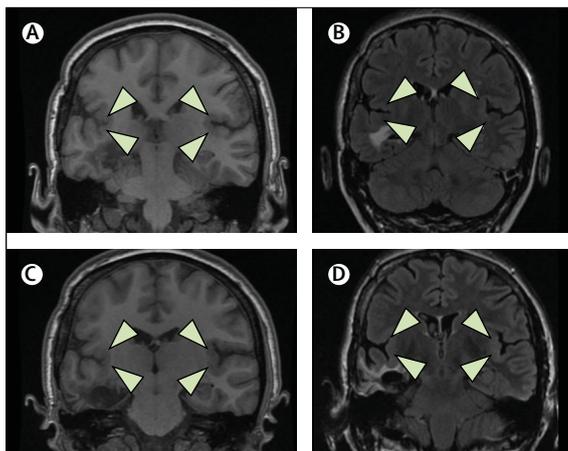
Epilepsy protocol MRI on a 45-year-old woman who had had two failed right temporal resective surgeries in the 1990s
